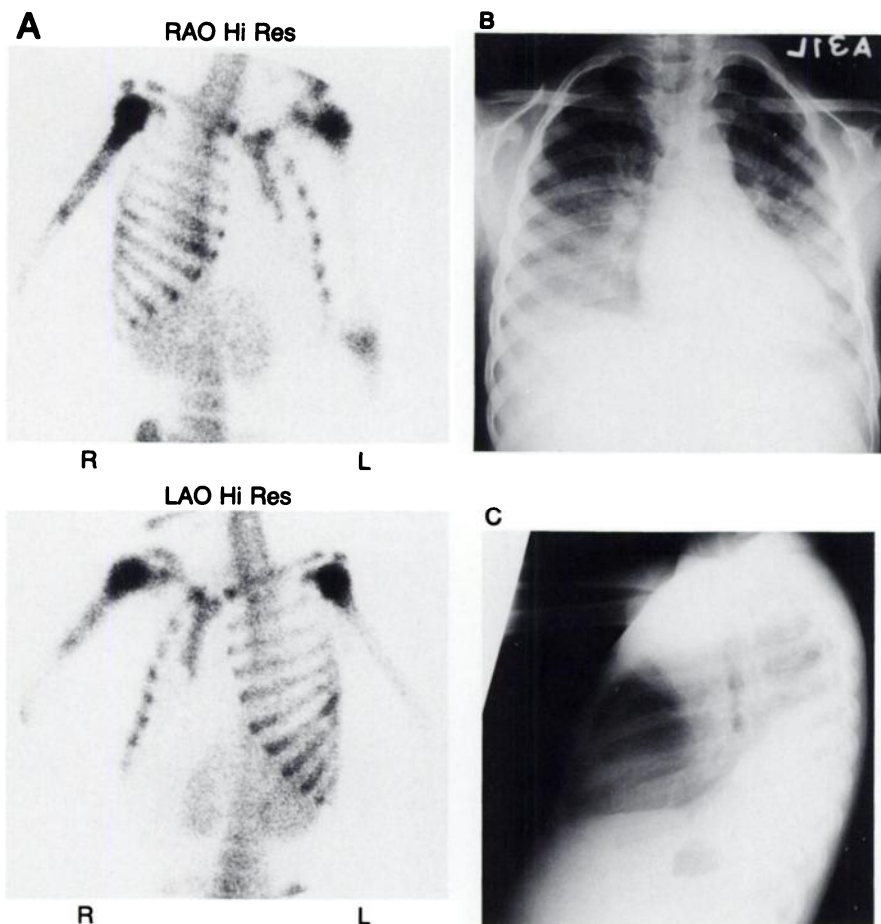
(A) An 11-yr-old male with sickle cell disease (Hgb SS). Short segments of two ribs on the right and one on the left have increased uptake. (B) There is also an extended area of increased uptake in the right proximal humerus. (B, C) Posterior-anterior and lateral chest radiographs demonstrate extensive lower lobe infiltrates.
